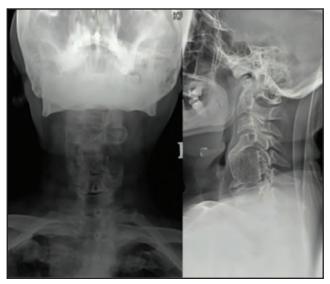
Cervical radiograph demonstrating bridging osteophytes involving C4, C5, C6 and C7, suggesting disseminated idiopathic skeletal hyperostosis (DISH)
